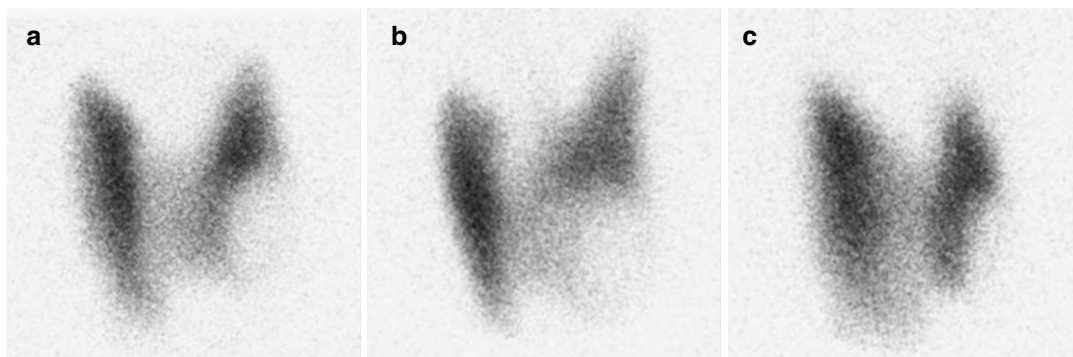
Thyroid scintigraphy of a “cold” thyroid nodule. A 15-year-old female was found to have a thyroid nodule during a preoperative evaluation, and ultrasound confirmed a 2 cm nodule with mixed solid and cystic components in the lower pole of the left lobe of the thyroid gland. Thyroid function tests showed a TSH level of 0.95 mU/l (reference 0.7–5.0 mU/l). Iodine-123 scintigraphy was performed with pinhole images of the thyroid
